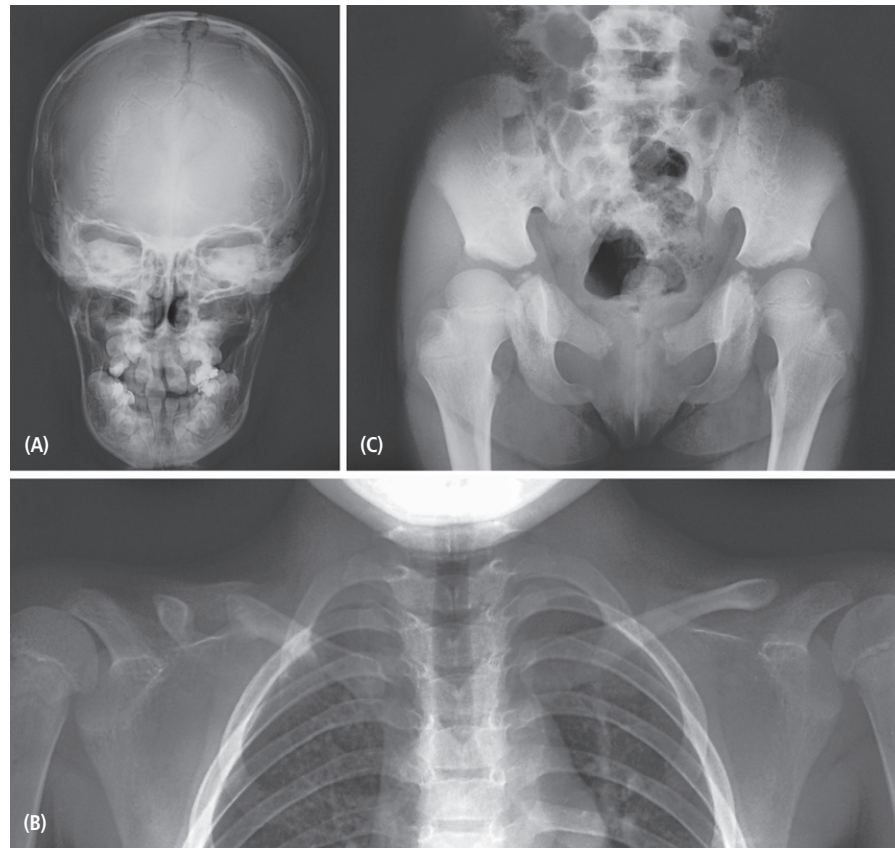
Radiographic analysis of the skeleton of the 10-year-old girl seen in Case 1. Radiographs of the (A) skull, (B) chest, and (C) pelvis.
